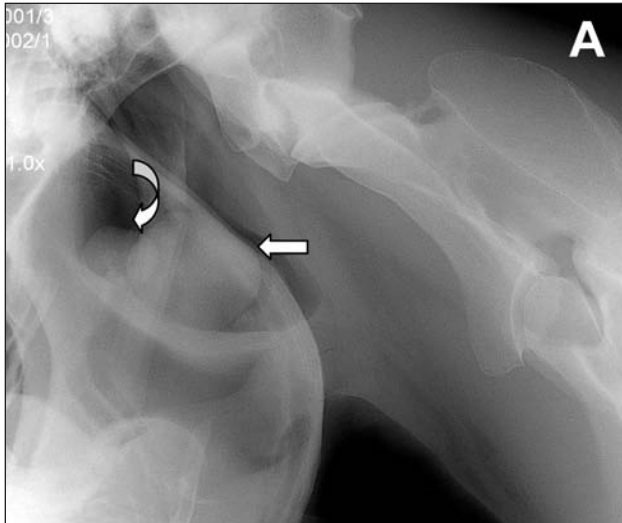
Same radiographic views as in Figure 1. On the left lateral (A) view, there is a small (curved arrow) and a large (straight arrow) irregular soft tissue opacity in the guttural pouch. On the ventrodorsal (B) view, there is a large (arrowheads), spherically shaped density in the left guttural pouch.
